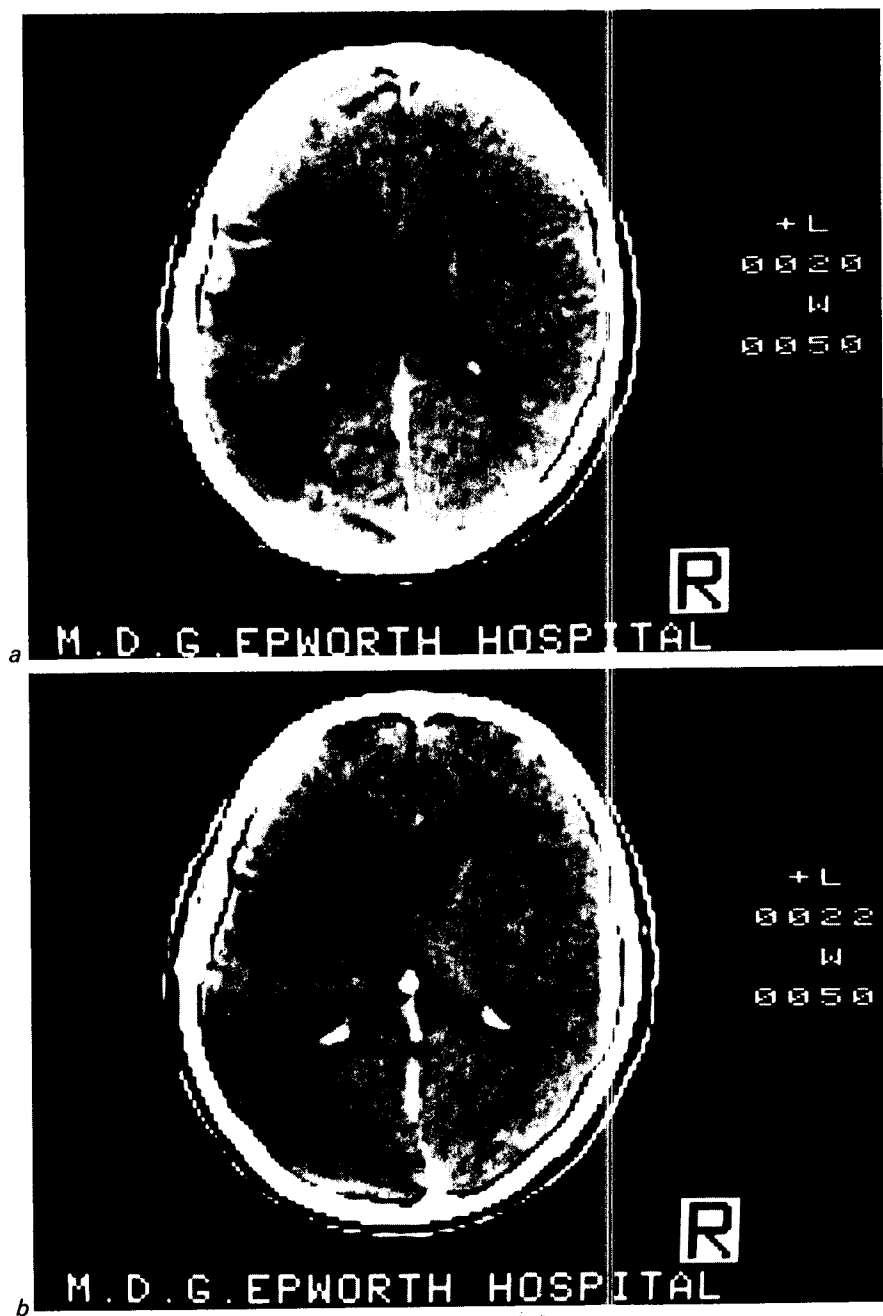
CT brain scan views, nearly two and a half years after the cerebral infarct.
